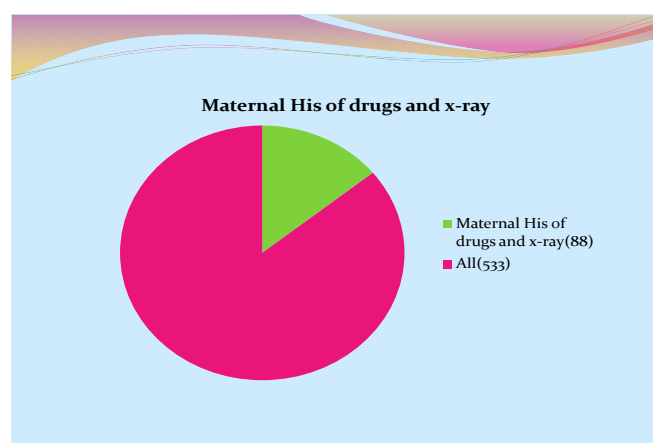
Frequency of cases with CHD related to maternal history of drug use & X-ray irradiation during pregnancy .
